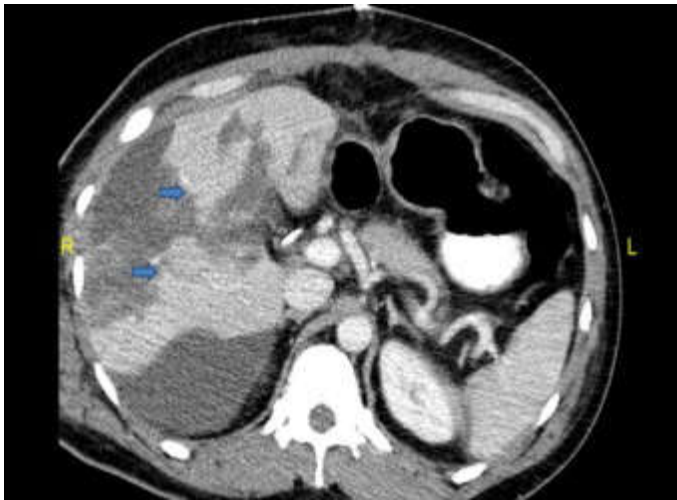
CT scan showing grade 4 multiple liver lacerations
